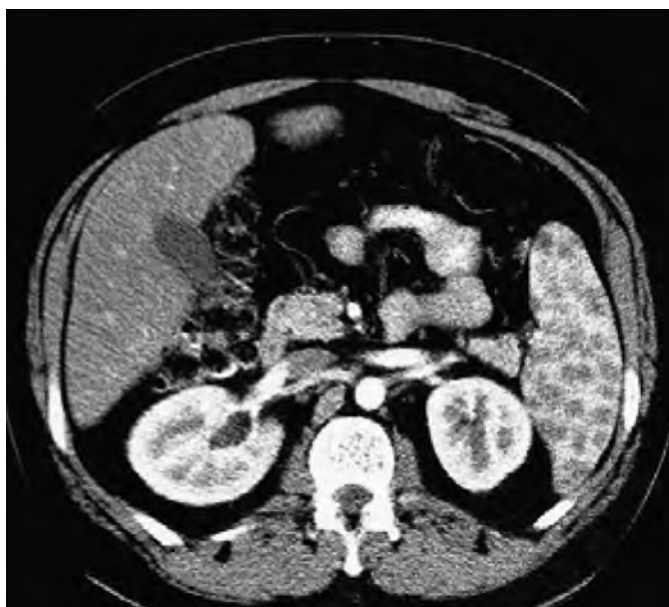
Sarcoidosis. Contrast-enhanced CT obtained in the portal venous phase shows numerous hypodense nodules.
